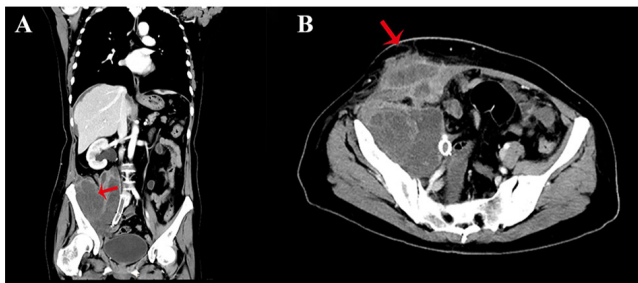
Representative CT scan of the abdomen and pelvis. (A) Coronal CT scan for multiple metastases within the pelvic cavity and abdominal cavity (arrow). (B) Horizontal CT scan for rupturing of metastases (arrow). CT, computed tomography.
